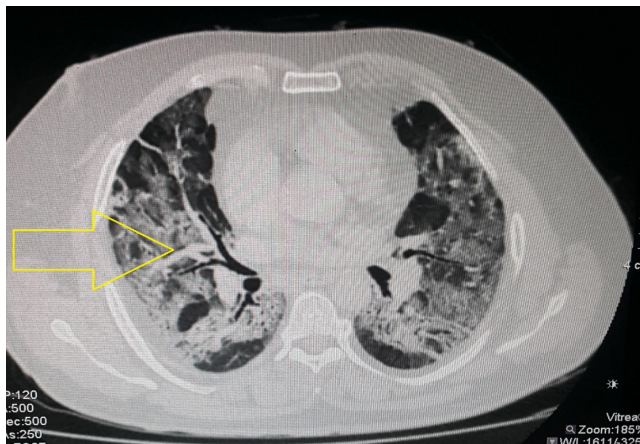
HRCT axial section showing dilated vessels along the ground glass opacity in right middle lobe
